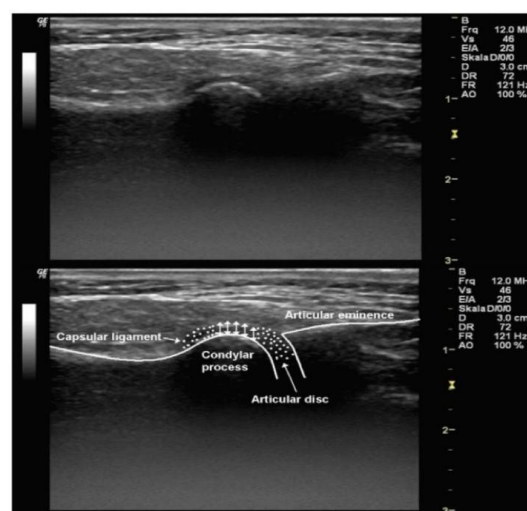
Ultrasound image showing anatomy of TMJ.
